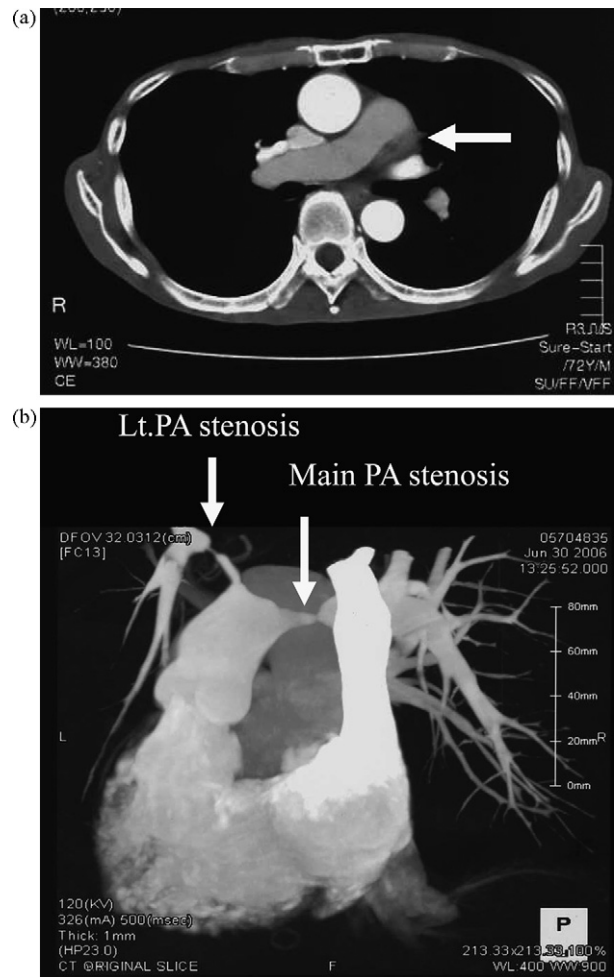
Enhanced chest computed tomography showed thrombus in the left pulmonary artery disappeared (A) but severe stenosis in the main trunk and left pulmonary artery (B).
